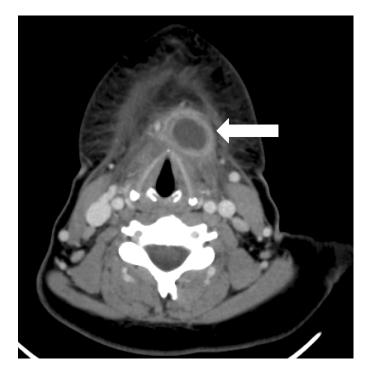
CT of the neck with contrast showing an enhancing, wellcircumscribed lesion located in the anterior neck at the level of the thyroid cartilage.
